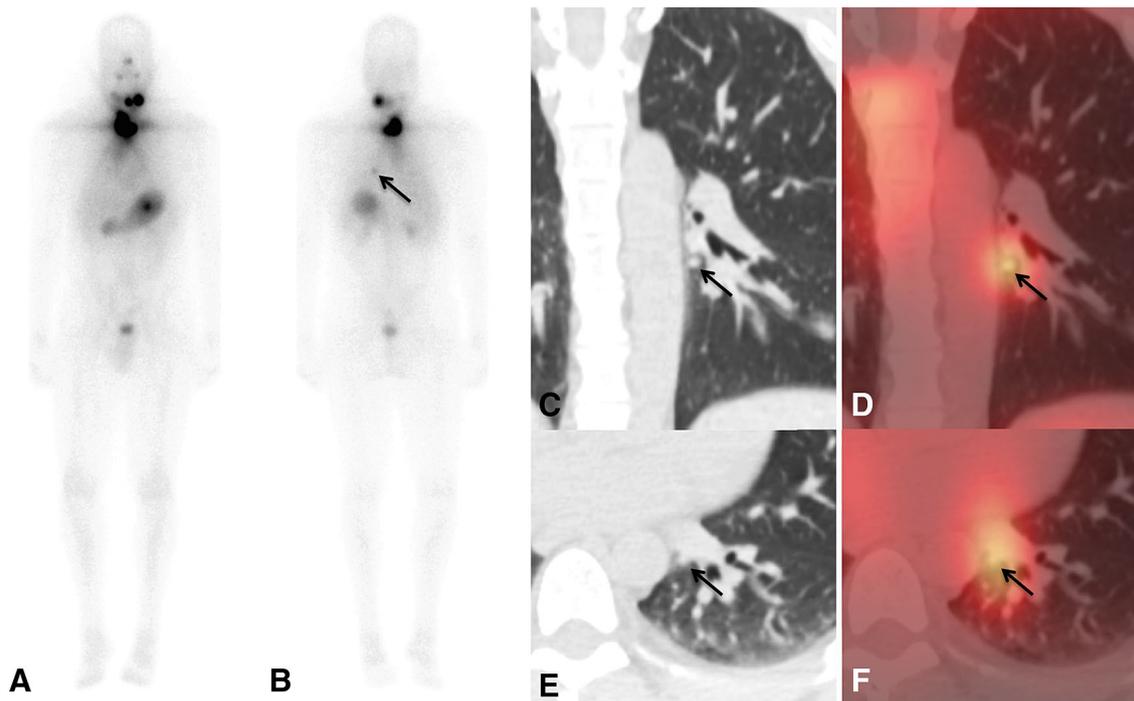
Distant metastases: Radioiodine-avid lung metastases. Post-ablation I-131 whole-body planar and SPET-CT scan in a 36-year-old male with papillary thyroid cancer. Anterior (a) and posterior (b) whole-body planar images demonstrate a subtle focus of activity in the left thorax (arrow), which is better visualized on the posterior image. Coronal
